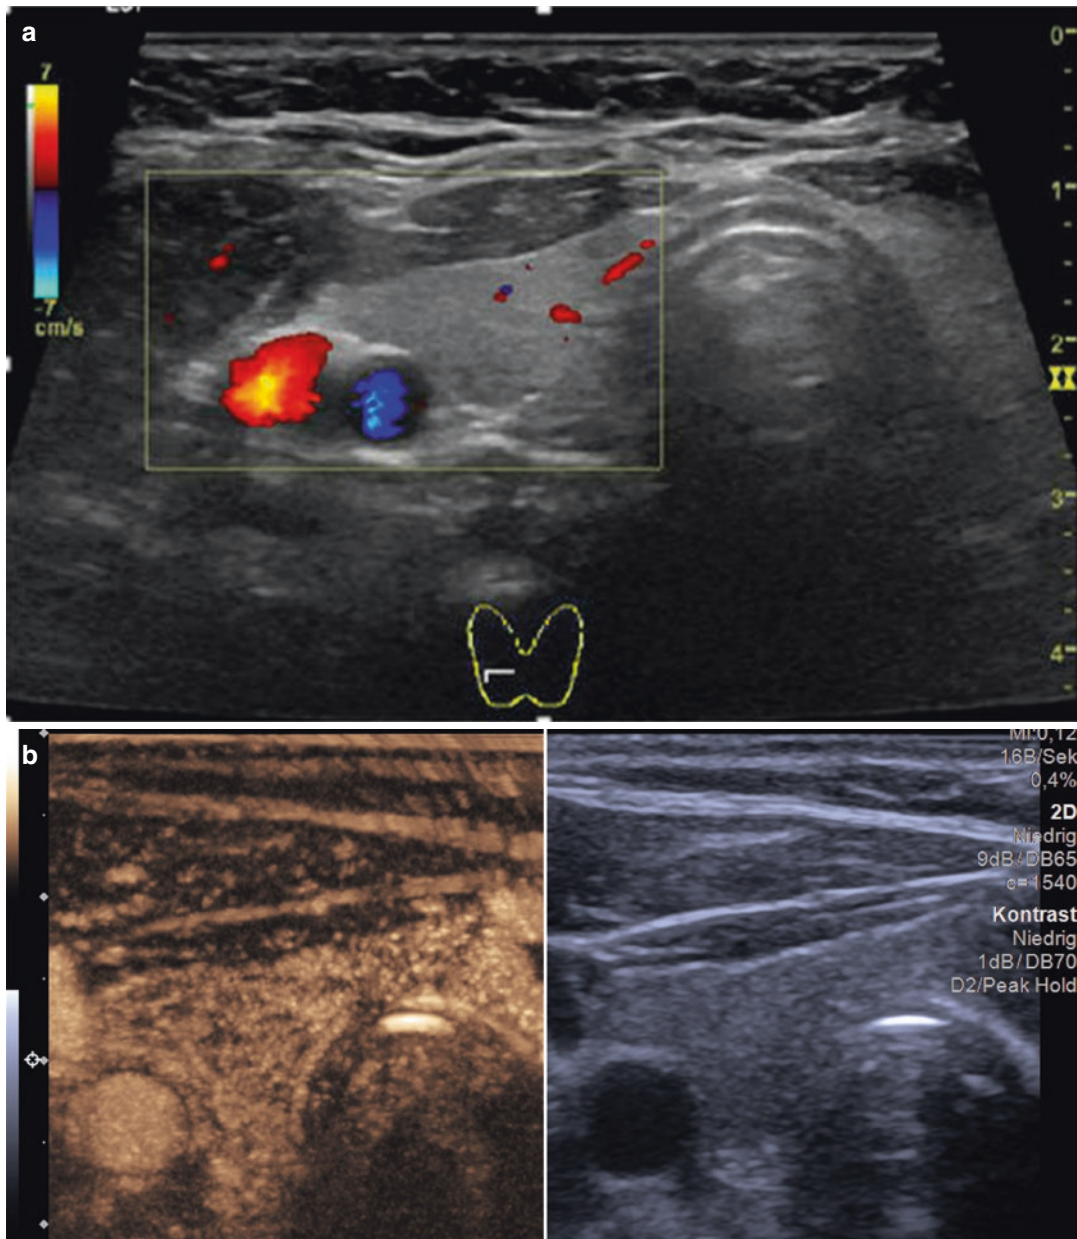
Normal thyroid gland on color Doppler ultrasound (CDUS) (a) and contrast-enhanced ultrasound (CEUS) (b; left image: after contrast agent application;
